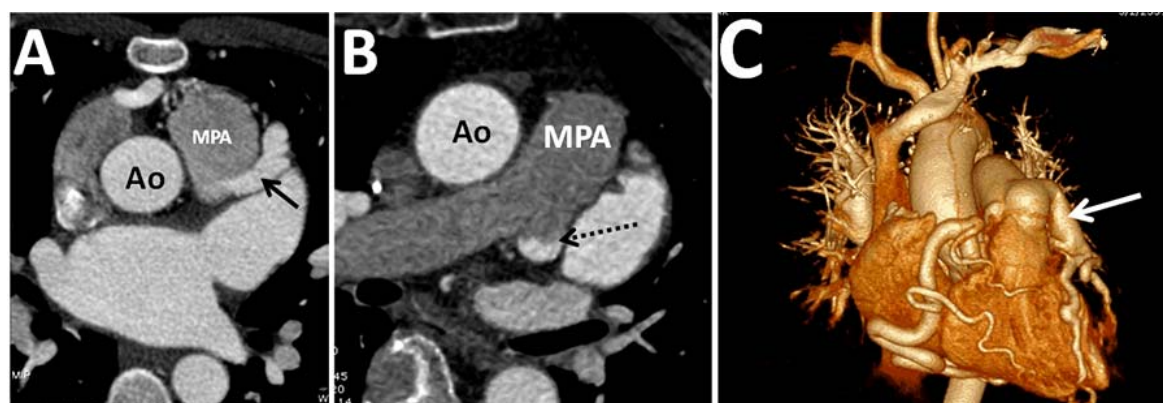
Dual-source computed tomography coronary angiography axial (A and B) and three-dimensional volume-rendered (C) images showing anomalous left coronary artery (A and C; arrow) from a main pulmonary artery (ALCAPA) and retrograde of contrast from the left coronary artery into the pulmonary artery (B; dashed arrow) due to steal phenomenon. (Ao; aorta, MPA; main pulmonary artery).
